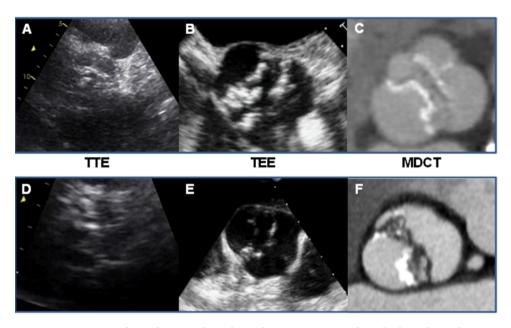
Comparison of transthoracic echocardiography (TTE), transoesophageal echocardiography (TEE) and multi-detector row computed tomography (MDCT) for the detection of bicuspid aortic valve (BAV) stenosis. Examples of BAV with a fusion raphe (*panels A-C*) and BAV without a fusion raphe (*panel D-F*) are shown. For both examples, TTE (*panels A and D*) has insufficient accuracy to correctly detect the presence of BAV and its specific morphology. TEE (*panels B and E*) shows a better accuracy for BAV diagnosis. MDCT (*panels C and F*) allows for optimal detection of BAV and the presence and location of raphes, especially when leaflet calcification is present.
